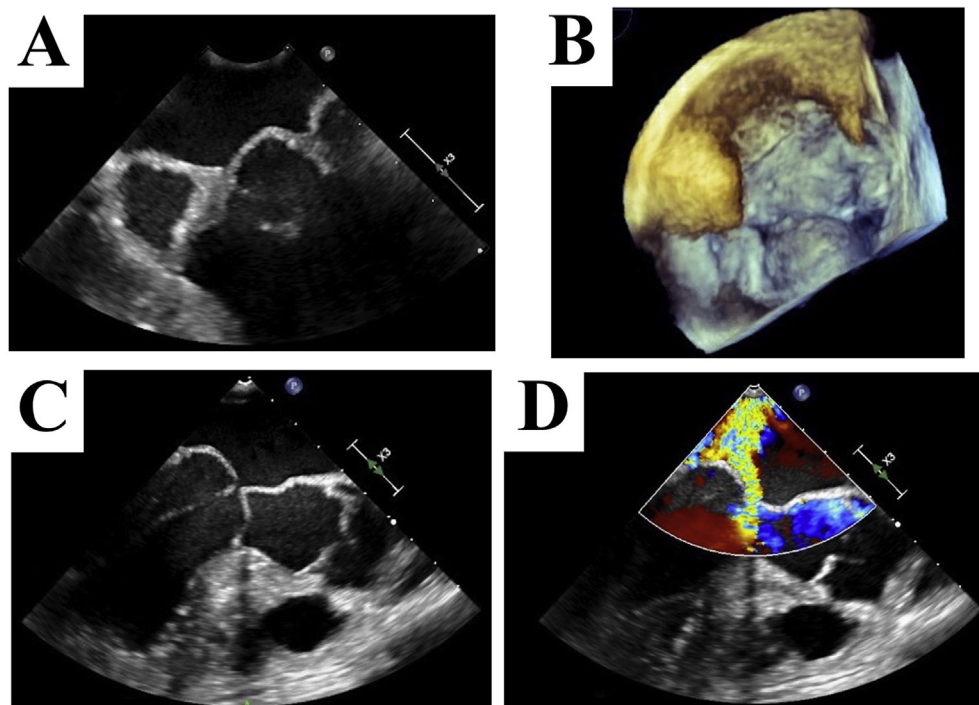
Pre-MitraClip TEE. Midesophageal four-chamber view at 0° (A), three-dimensional surgeon's view (B), and midesophageal long-axis view and color Doppler at 145° (C, D) demonstrating Barlow's MV disease, severe posterior leaflet prolapse, SAM, and severe MR.
